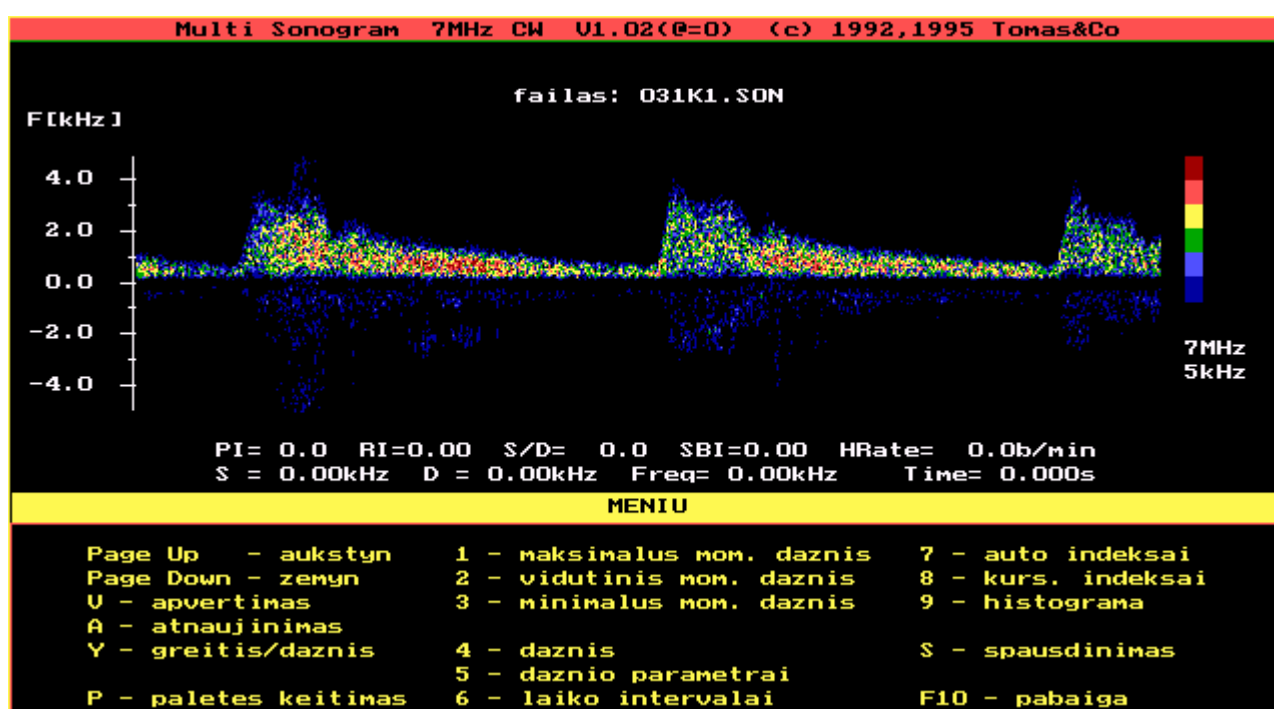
The Doppler curve of the normal blood flow in the ophthalmic artery of the healthy person
